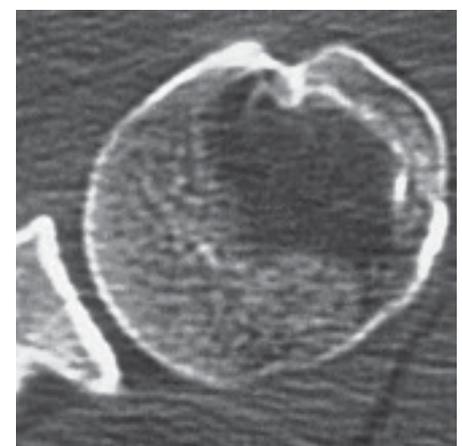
Lipoma. Axial CT showing that the lipoma has the tissue density of fat.
